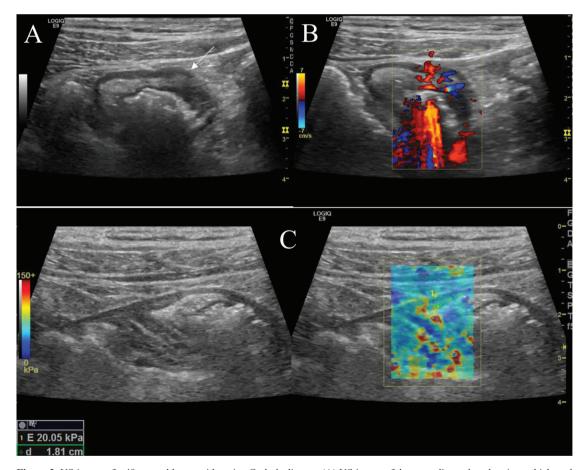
US image of a 48-year-old man with active Crohn's disease. (A) US image of the ascending colon showing a thickened bowel wall (arrow) and a target sign. (B) Color Doppler US image of the ascending colon showing Doppler signals in both the intestinal wall and the surrounding mesenteric fat (Limberg score: Grade 4). (C) SWE measurements of the ascending colon were obtained using a circular region of interest (ROI) placed on the bowel wall. The 2D-SWE map (right side) and grayscale image (left side) are shown. (US: Ultrasonography, SWE: Shear wave elastography).
